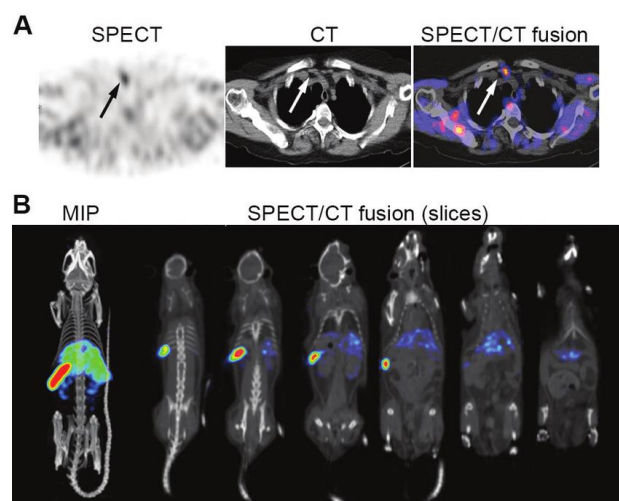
Examples of two SPECT/CT imaging applications: (A) – clinical, and (B) - preclinical applications; both showing at right the fused SPECT/CT slices. Adapted from [5,6].
